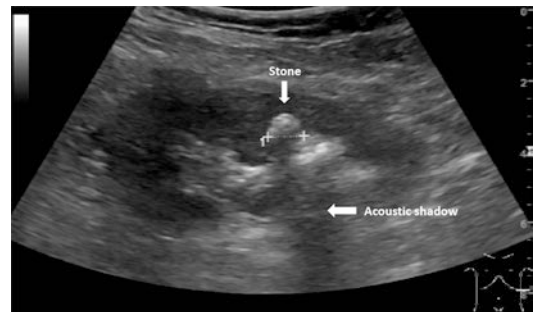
Ultrasonography [US] of kidney with a stone in the middle calyx. (The stone strongly reflect ultrasonic waves and appears as a bright echogenic structure with an acoustic shadow behind, due to the fact that that the ultrasonic waves are unable to penetrate through the stone)
